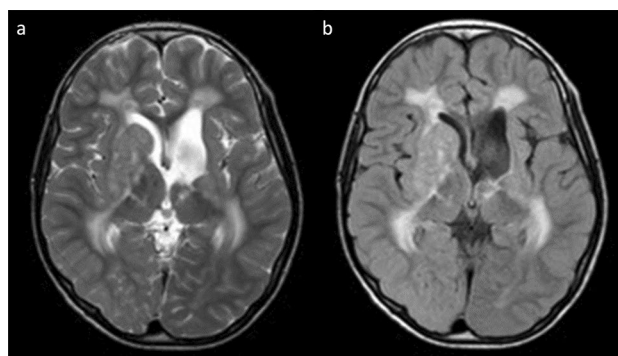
COLGALT1*-related disorder in a 12-year-old, male patient with severe developmental delay, epilepsy, spastic quadriplegia. Axial T2-weighted imaging (a) and FLAIR imaging (b) demonstrated porencephaly in the left hemisphere with destructive changes of the basal ganglia and bilateral leukoencephalopathy with mild atrophy. Hyperintense lesions were also observed in the right basal ganglia, posterior limb of the internal capsule, and bilateral thalami (reprinted with permission from Reference [35])
